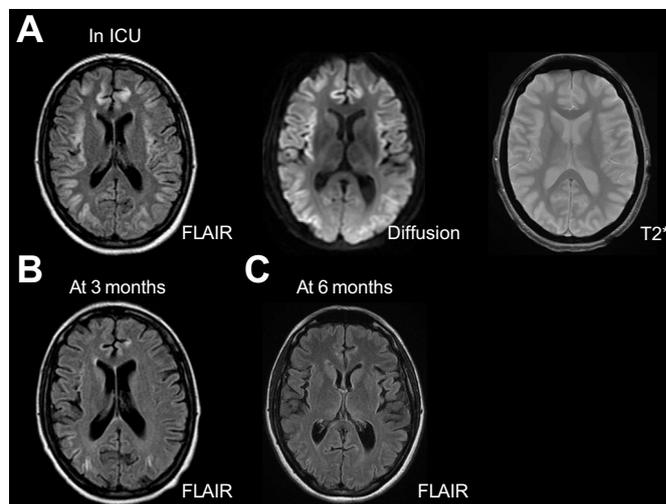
Brain MRI (A) MRI imaging in ICU showing diffuse cortical hypersignals on both FLAIR and diffusion-weighted sequences. T2* weighted sequence was normal (B) Partial disappearance of the cortical hypersignals at 3 months; (C) Total disappearance of the cortical hypersignals at 6 months. FLAIR, fluid attenuated inversion recovery; ICU, intensive care unit.
